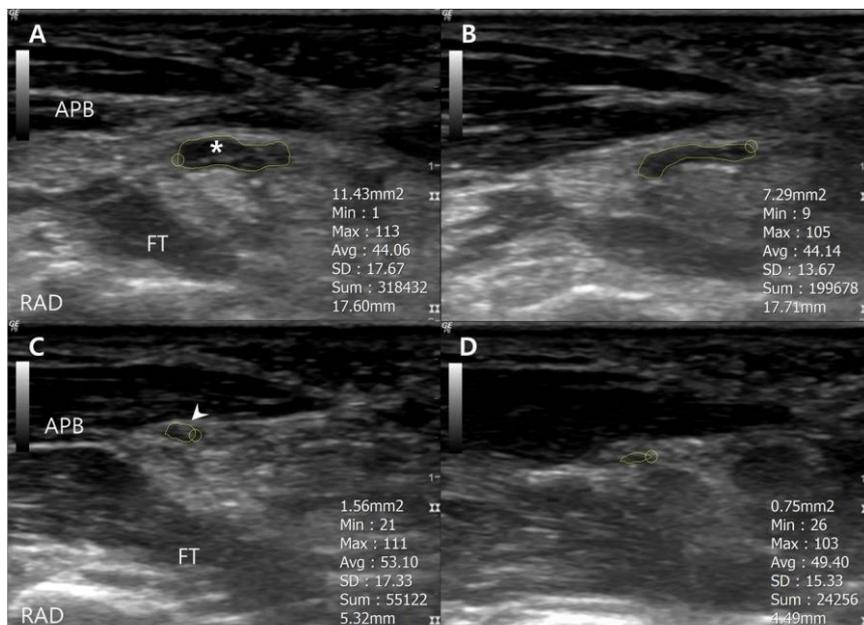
Ultrasound findings of the median nerve and the recurrent motor branch. Right median nerve (A) is enlarged just distal to the transverse carpal ligament compared to left median nerve (B). Swollen radial-side motor fascicles (asterisk) within the median nerve are observed. (C) Thickened recurrent motor branch (arrow head) of right median nerve is found while the median nerve branches distal to the transverse carpal ligament. (D) Left recurrent motor branch of the median nerve at the same level.
